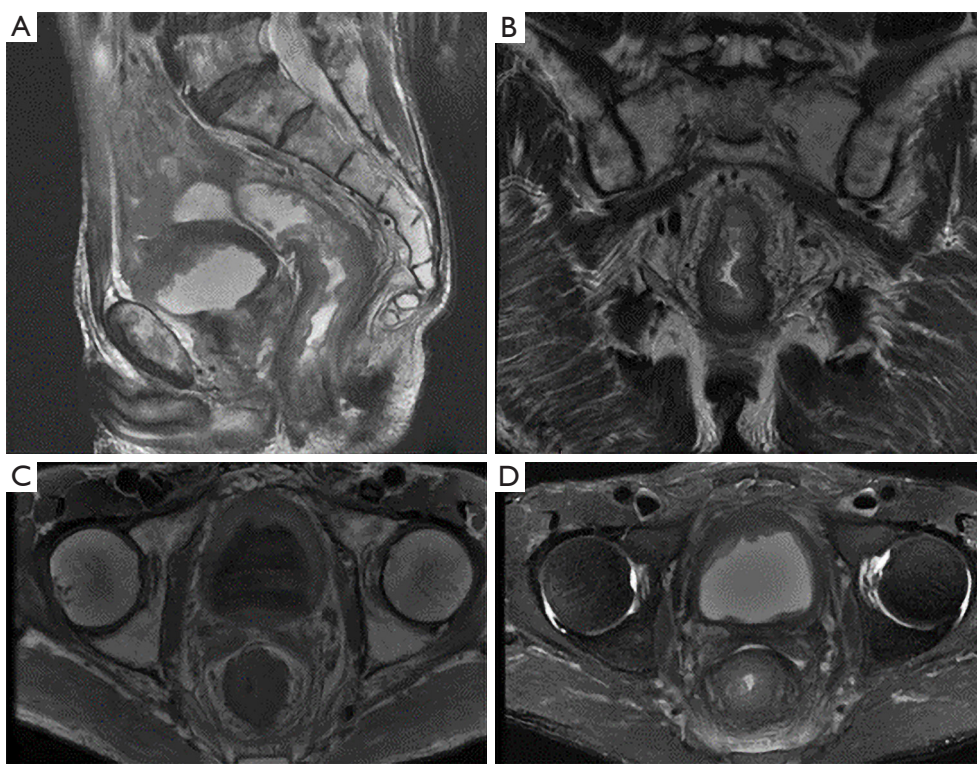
Rectal MRI indicated that the rectal wall and bladder wall were thickened. (A) Preoperative sagittal MRI, T2WI; (B) coronal MRI, T2WI; (C) transverse MRI, T1WI; (D) transverse MRI, T2WI-FS. MRI, magnetic resonance imaging; T2WI-FS, T2-weighted imaging fat suppression.
